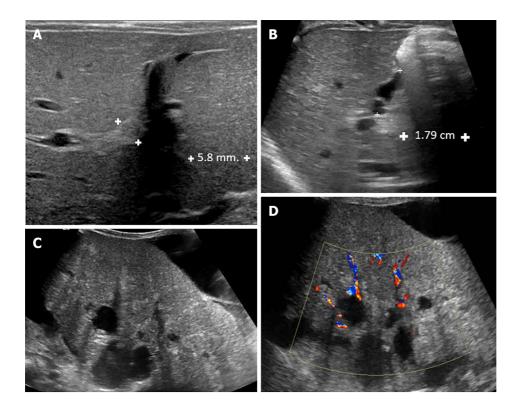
Ultrasound finding of biliary atresia. A: A 25-d-old boy presented with prolong jaundice. Ultrasonography of the upper abdomen showed a thick echogenic band located anterior to the right portal vein and measuring approximately 5.8 mm in thickness, representing a positive triangular cord sign; B: A 49-d-old boy presented with prolonged jaundice and pale stools. Ultrasonography of the upper abdomen revealed: (1) A small size of gallbladder, measuring a maximal length of approximately 15.4 mm; (2) Lack of smooth, complete echogenic mucosal lining with an indistinct wall; and (3) Irregular gallbladder contour. These findings are consistent with a positive gallbladder ghost triad. The common bile duct was not visualized; C and D: An 11-month-old boy presented with clinical obstructive jaundice with abdominal distension. Ultrasonography of the upper abdomen revealed multiple irregular cystic lesions of various sizes in the central region of the right and left hepatic lobes and at the porta hepatis. Some cyst had echogenic content. Liver cirrhosis and ascites were noted.
